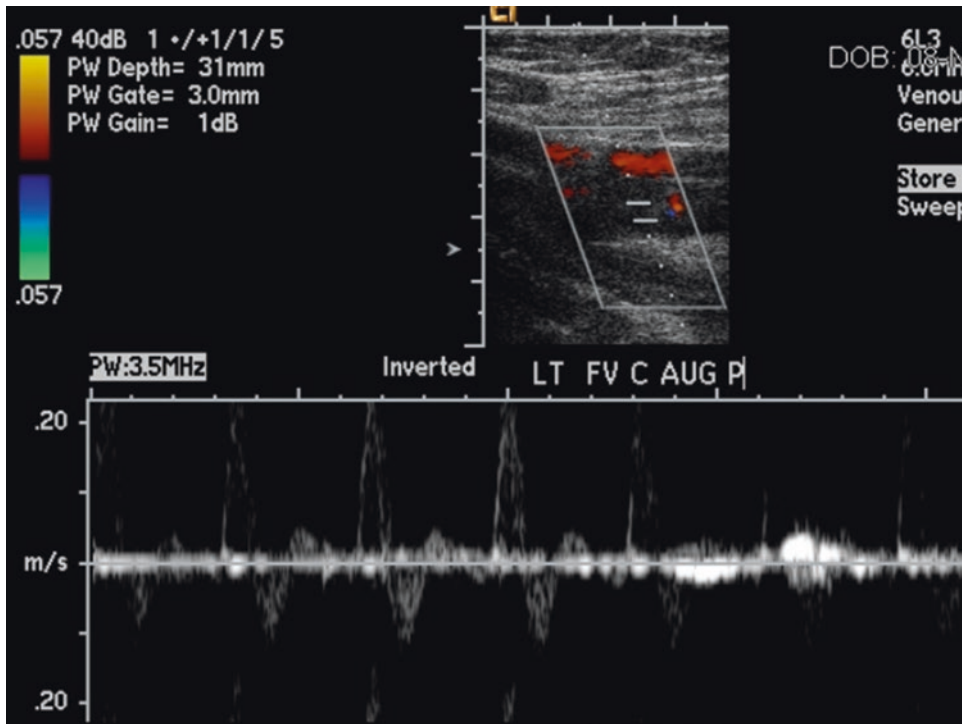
Color Doppler imaging (*above*) shows the left femoral vein where it is joined by the deep femoral vein in the same 39-year-old patient shown in Figs. 13.18, 13.19, and 13.20. The waveform analysis (*below*) indicates no blood flow in the left femoral vein despite increased gain. The background spikes are caused by the adjacent femoral
